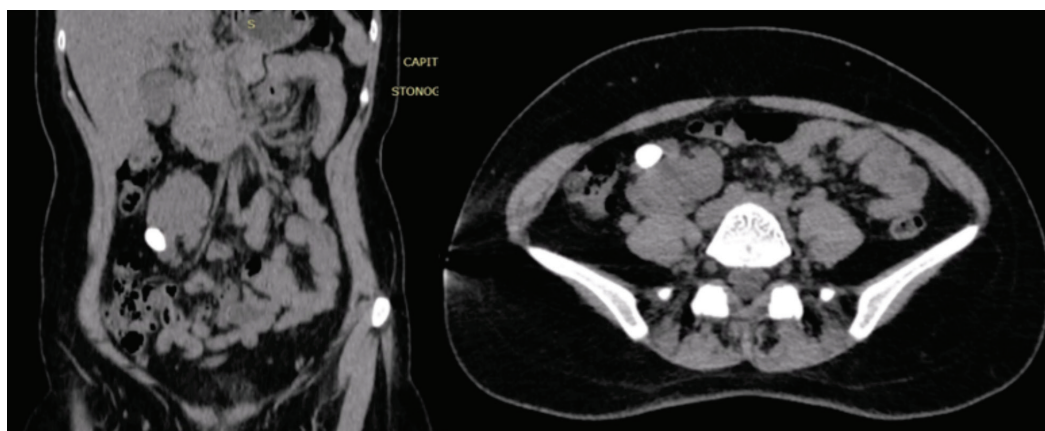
Coronal and axial cuts of the computed tomography stonogram showing the anteriorly rotated ectopic right kidney with a 2 cm middle calyceal calculus
